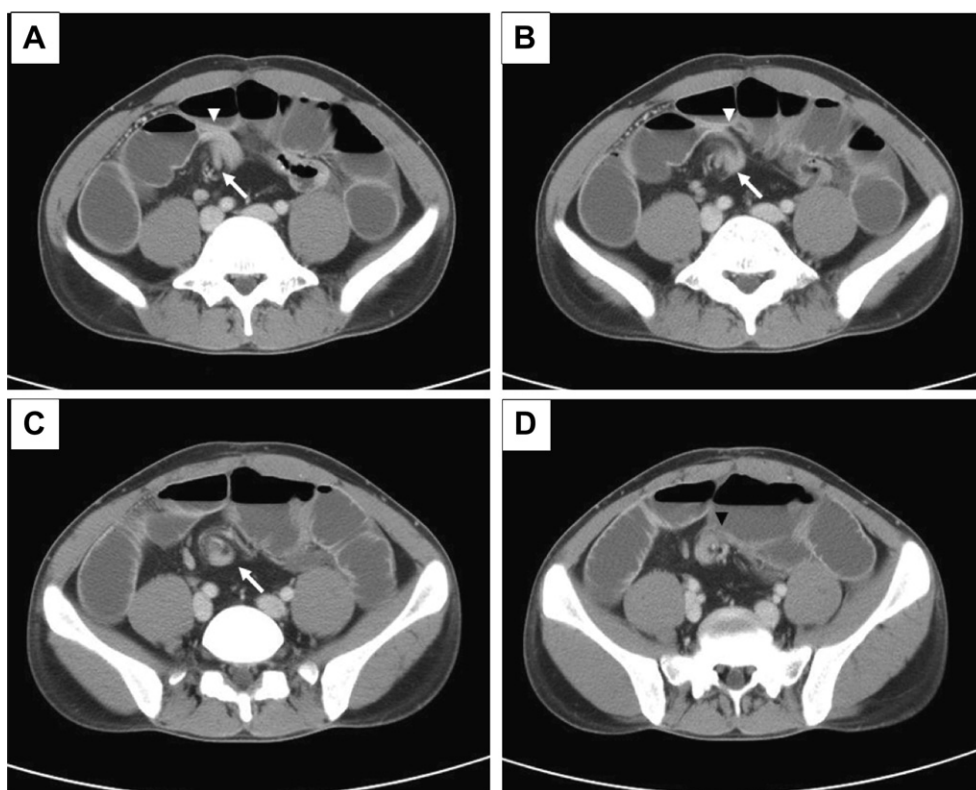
Contrast-enhanced computed tomography discloses a dilated small bowel with air–fluid levels in combination with a whirl sign (A–C, white arrows) composed of mesentery and its attachments, and the transitional zones (A, ileum side, white arrowhead) and sigmoid colon side (D, black arrowhead).
